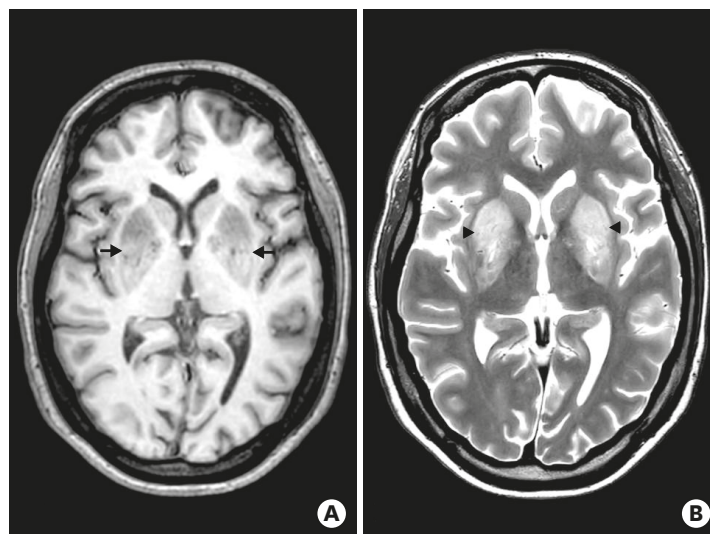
(A) Hyperintensities involving bilateral basal ganglia including globus pallidus and putamen (black arrows) on T1-weighted image. (B) Corresponding T2-weighted image showing diffuse hyperintensities (arrowheads).
